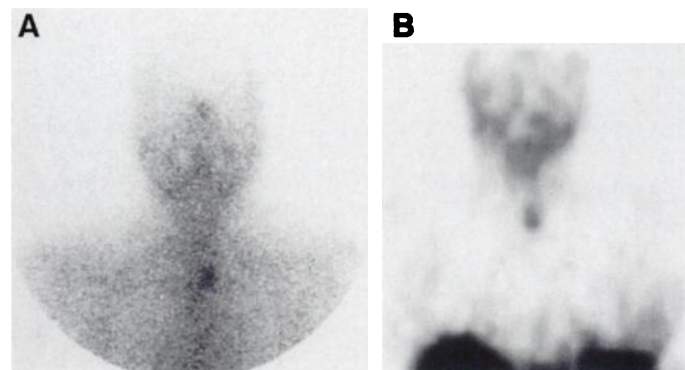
Somatostatin receptor scintigraphy anterior view (A) and coronal section (B) of the neck and chest shows pathological mediastinal uptake. Chest CT scan depicted a mass. Surgical finding was a lymph node metastasis.
